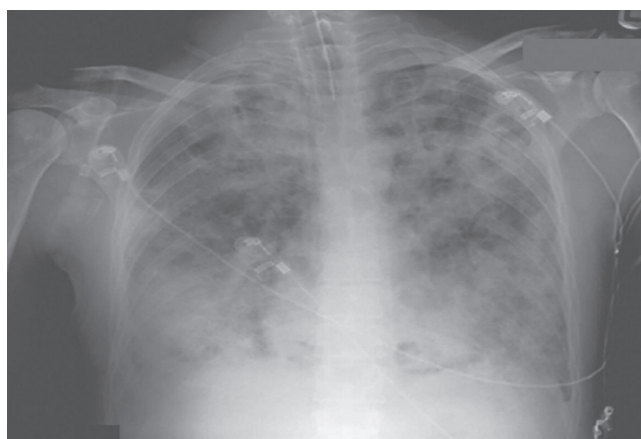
Radiographic image of a patient with ARDS. Bilateral diffuse infiltrates and opacities are seen, with a regular heart silhouette.
